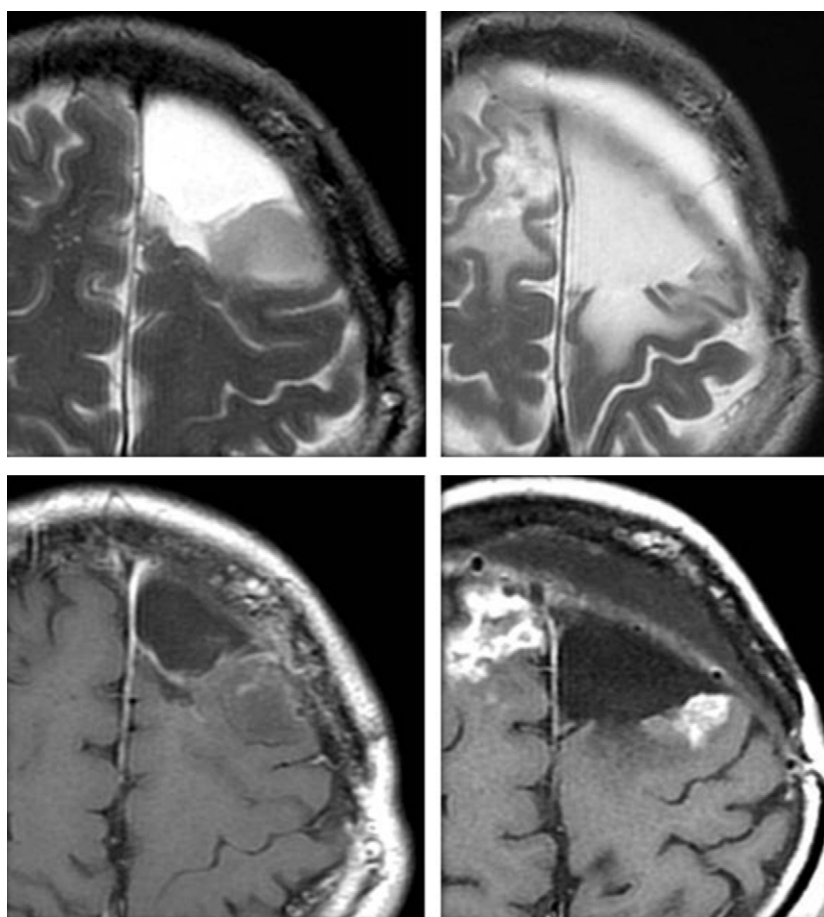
Case 2: right frontal GBM 33-year-old female. Left: Gd- and T2-MRI before BNCT, middle: Gd- and T2-MRI four years after BNCT.
